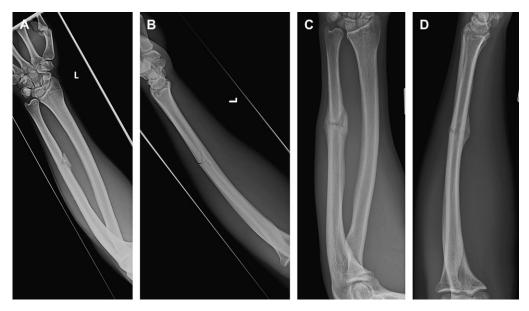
Trauma radiographs of a minimally displaced, comminuted, isolated ulnar shaft fracture in a 22-year-old male construction worker (A, B). This patient was initially treated in a long-arm cast and switched to a short-arm cast. This patient returned to construction work at 6 weeks postinjury in a below-elbow cast because of economic issues. Clinical union and bridging callous is seen at 12-week follow-up radiographs (C, D).
